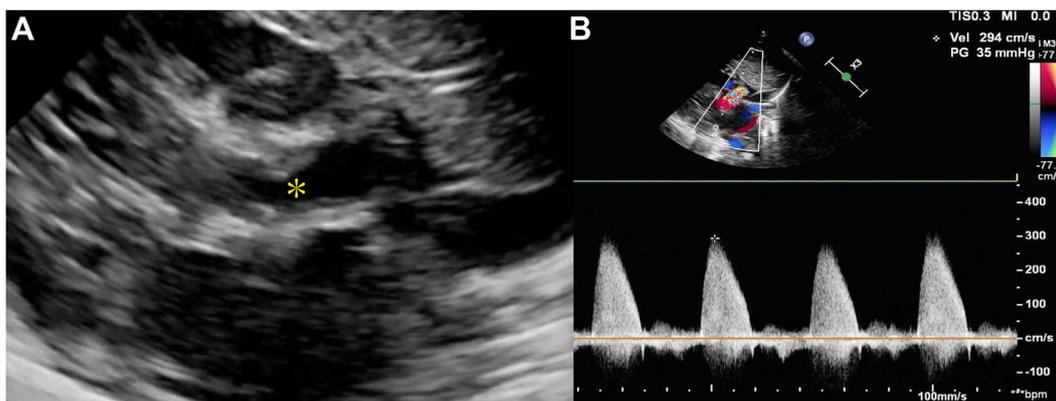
(A) Two-dimensional TTE, parasternal long-axis view, systolic phase, demonstrates the superior border of the sinus of Valsalva is markedly thickened and the lumen of the ascending aorta is narrowed (asterisk). (B) Two-dimensional TTE, suprasternal notch view with color-guided continuous-wave spectral Doppler interrogation demonstrates a high-velocity 2.94 m/sec jet corresponding to a peak gradient of 35 mm Hg.
